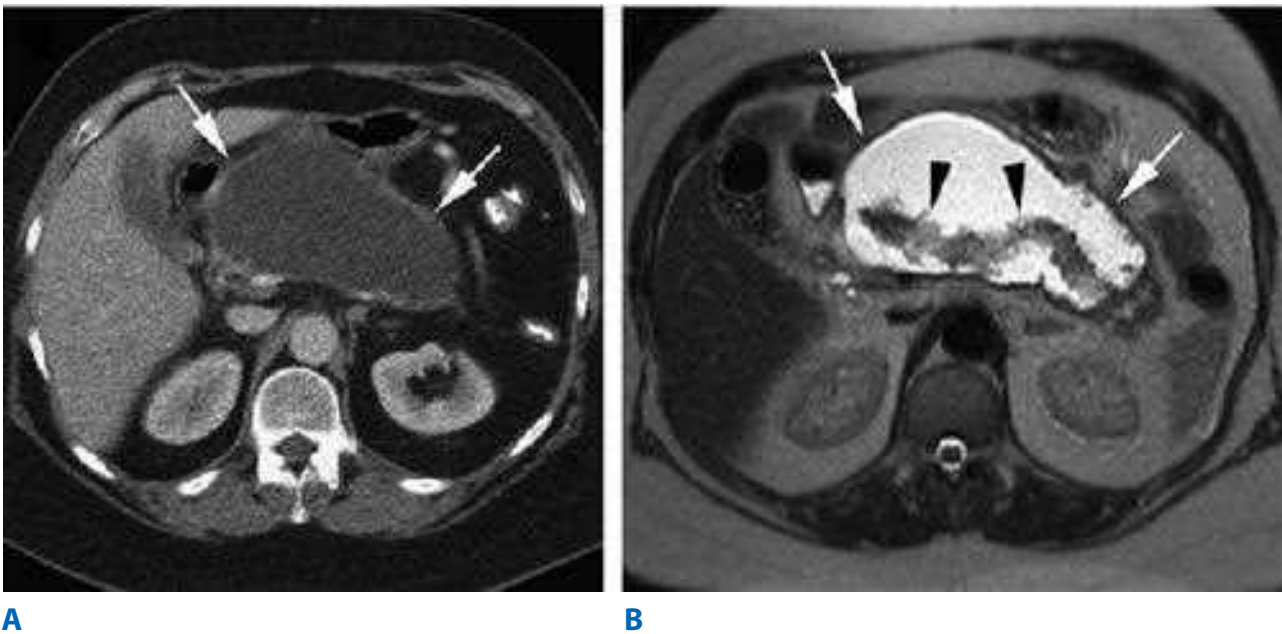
Corresponding CT (A) and MR (B) images of a patient with a symptomatic pseudocyst. CT image reveals a well circumscribed homogenous collection (arrows) exerting mass effect on antrum of stomach. The T2-weighted MR image clearly distinguishes necrotic pancreas (black arrows) from fluid (white arrows). (Reproduced with permission from Bollen TL et al. *Imaging of acute pancreatitis: Update of the revised Atlanta Classification*. Radiol Clin North Am. 2012;50:429. Copyright Elsevier.)
